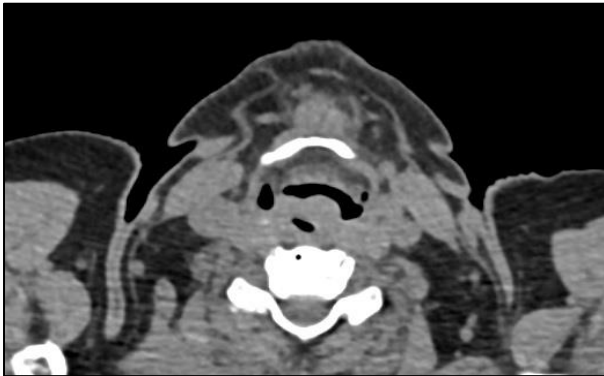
Computed tomography of neck axial section showing mass lesion in the larynx at the level of supraglottic and abutting the right aryepiglottic fold.
